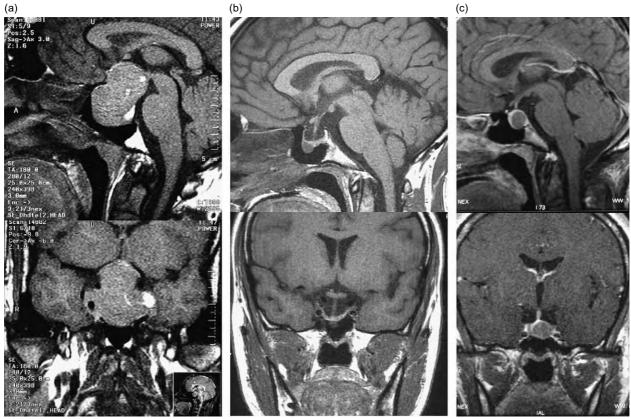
Coronal and sagittal T1-weighted MRI taken at diagnosis in three family members with pituitary tumors in association with an E174 frameshift *AIP* mutation. (a) The index case presented at 17 years of age with a large invasive pituitary macroadenoma, (b) his sister presented aged 25 with a 9×8 mm pituitary adenoma, and (c) the aunt of the two other patients presented at age 35 with a non-invasive pituitary macroadenoma. For (a), 3 mm cuts were used and for (b) and (c), 2 mm cuts were used.
